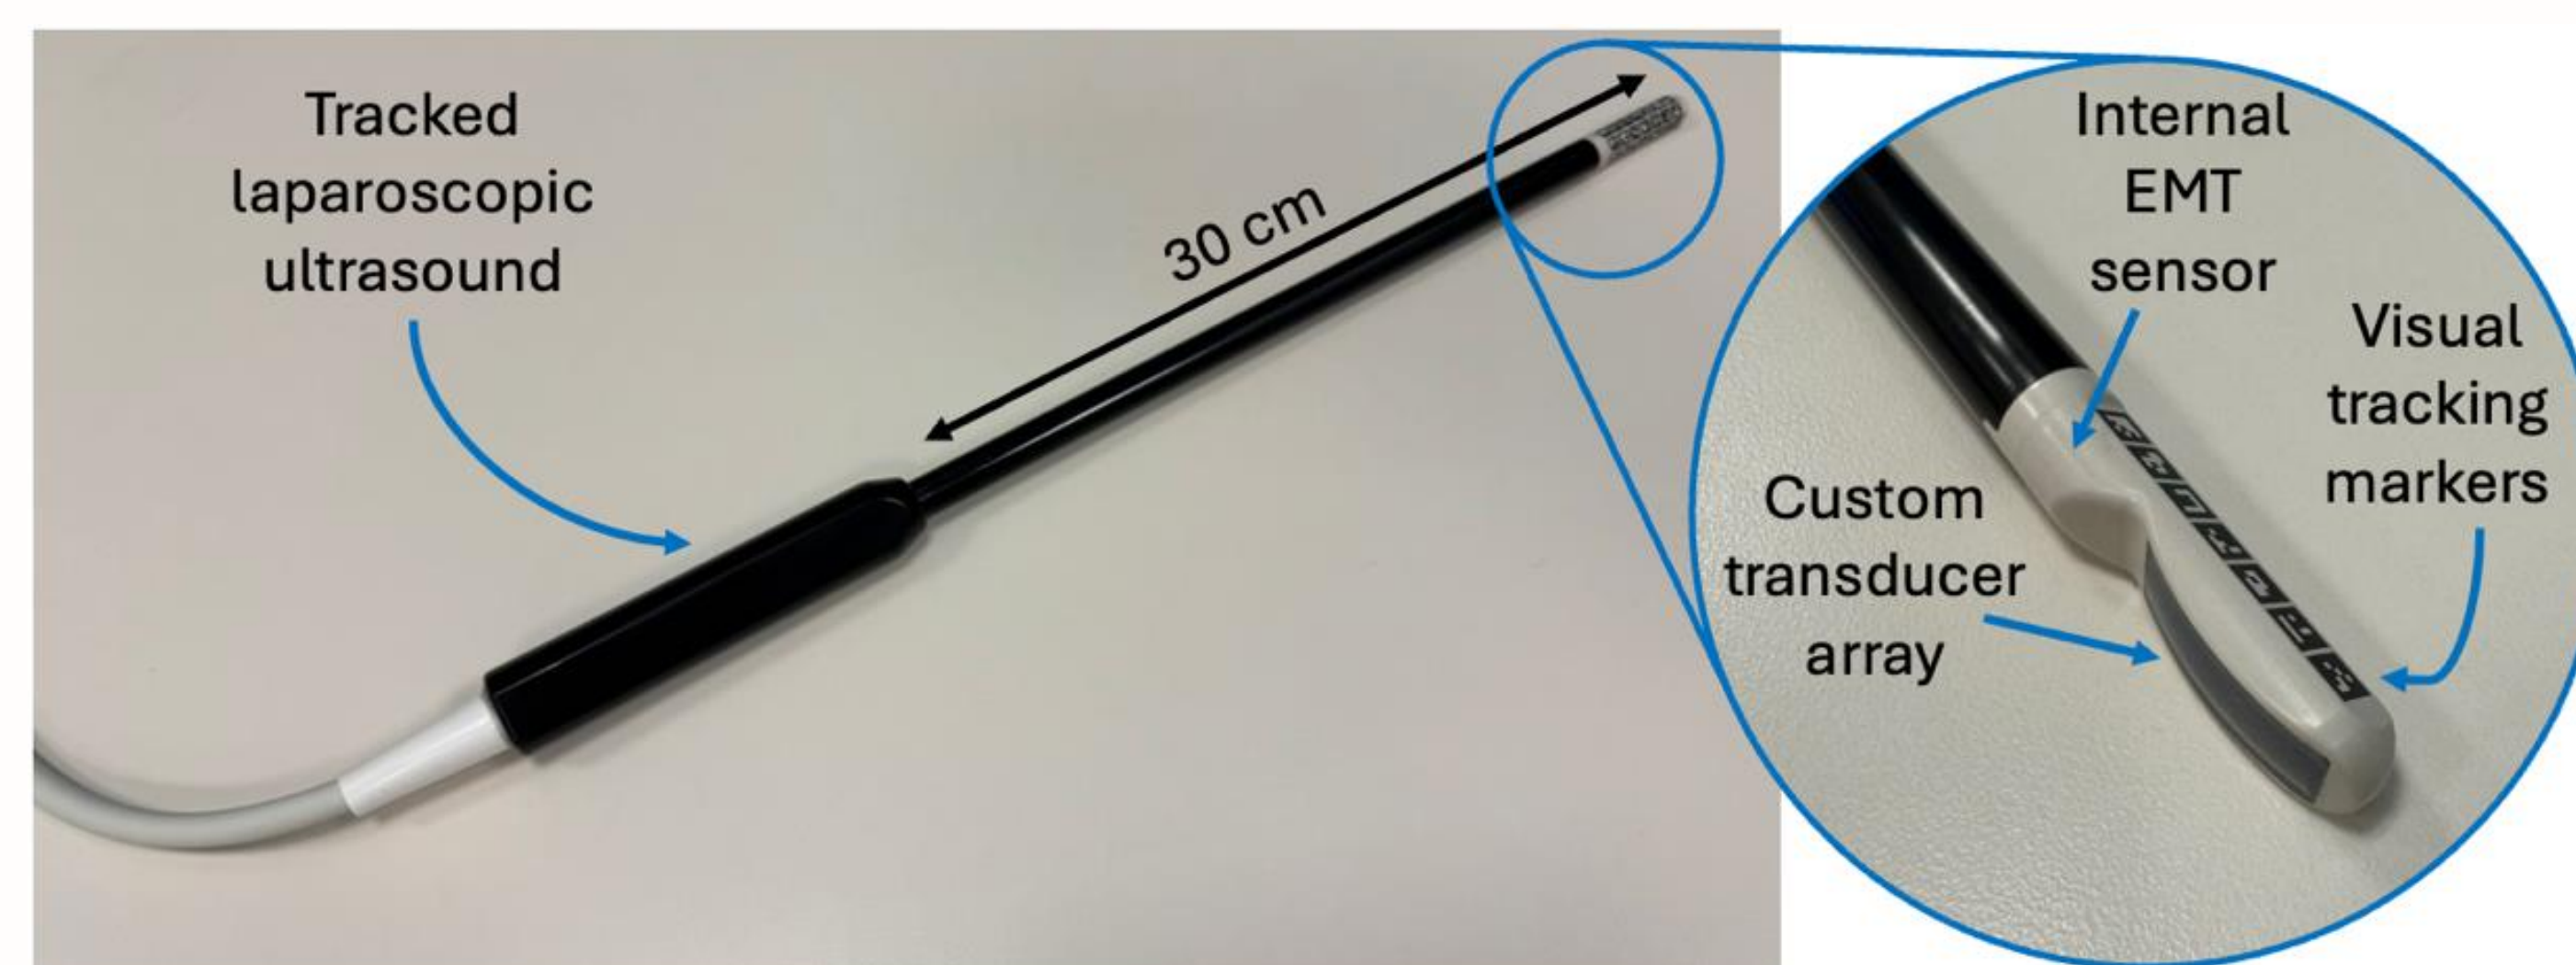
Laparoscopic ultrasound probe with dual electromagnetic and vision-based position tracking modalities built in.
